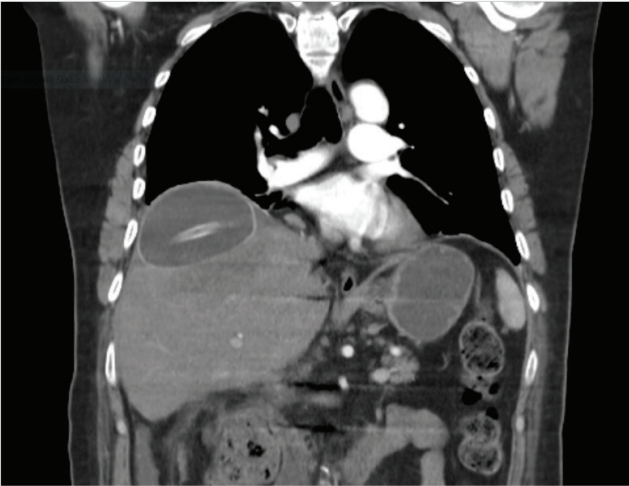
Postoperative CT image showing the Bakri balloon between the diaphragm and the liver.
